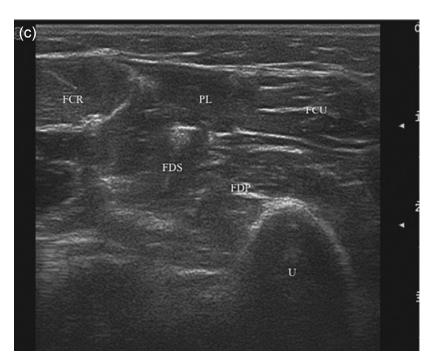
Clenching the fist. (a,b) Muscles utilized in clenching the fist. (c) Transverse ultrasound image of flexor muscles in the left forearm. FCR, flexor carpi radialis; PL, palmaris longus; FDS, flexor digitorum superficialis; FCU, flexor carpi ulnaris; FDP, flexor digitorum profundus; U, ulna.
